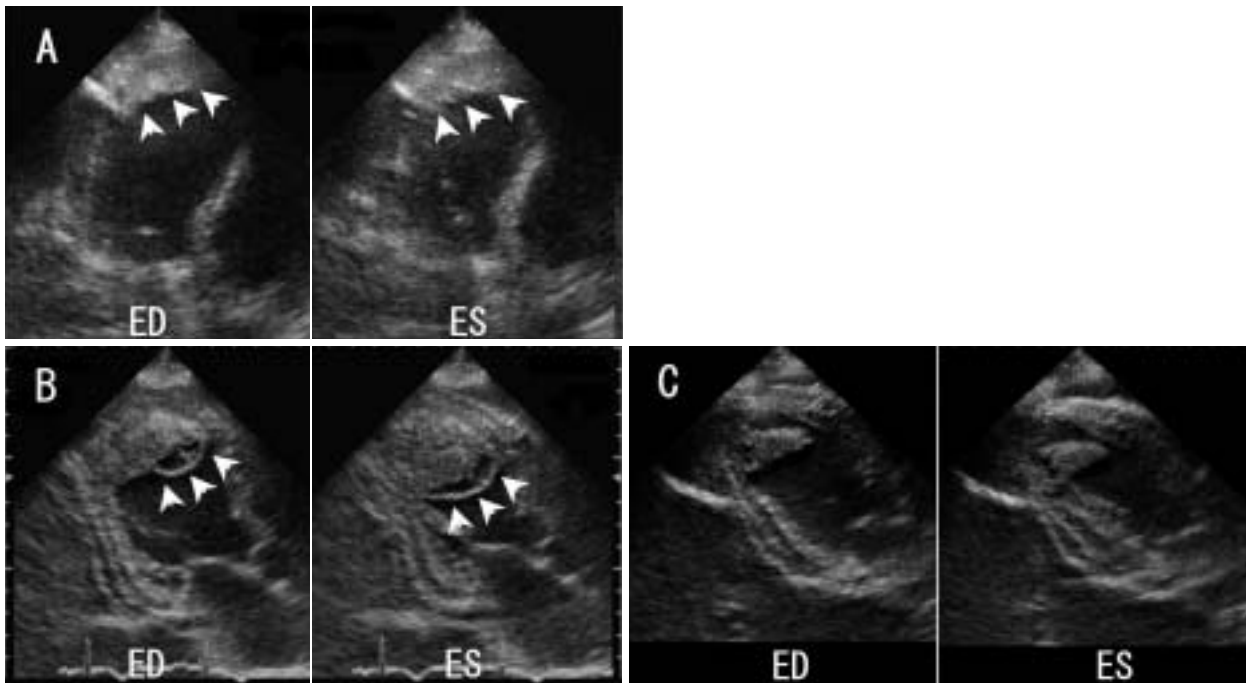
Serial changes in echocardiograms
